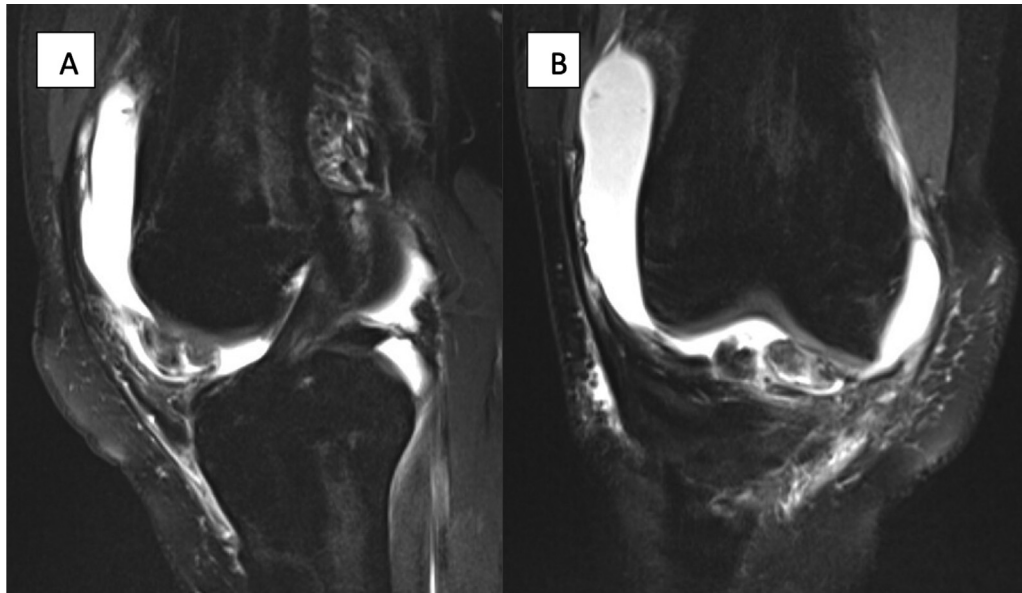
TSGCT case example. A 23-year-old woman who presented with worsening right knee pain after episode of deep flexion. She has had intermittent mechanical symptoms and effusions for many years. On examination, there was a large effusion and range of motion from 0 to 115 degrees. MRI demonstrated a significant effusion with an associated large pedunculated soft-tissue mass in the anterior compartment seen on (A) sagittal and (B) coronal STIR images.
